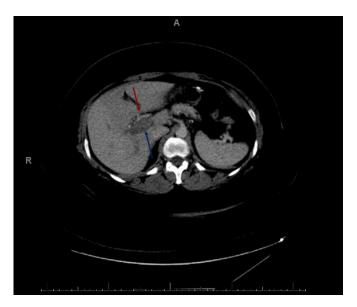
Axial CT abdomen/pelvis with oral and intravenous contrast showing opacification of the hepatic artery (red arrow) and unopacification and distension of the main portal vein (blue arrow), suggestive of an acute thrombus.
